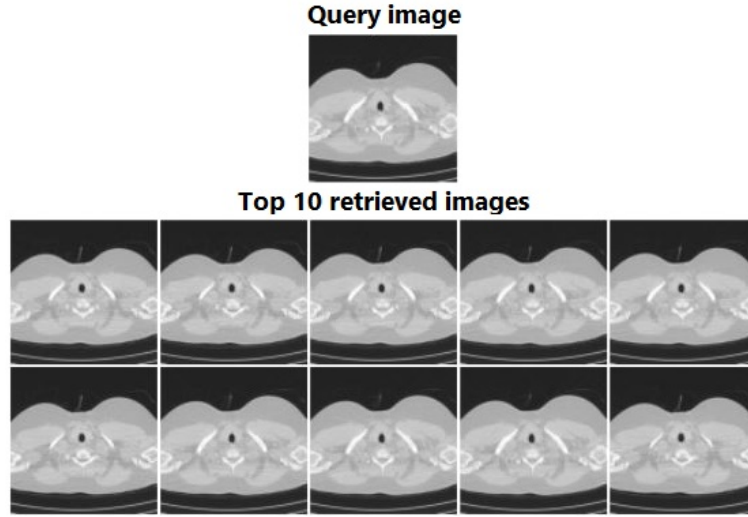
Retrieved images for an EXACT09-CT dataset query using RbQE with AlexNet.
